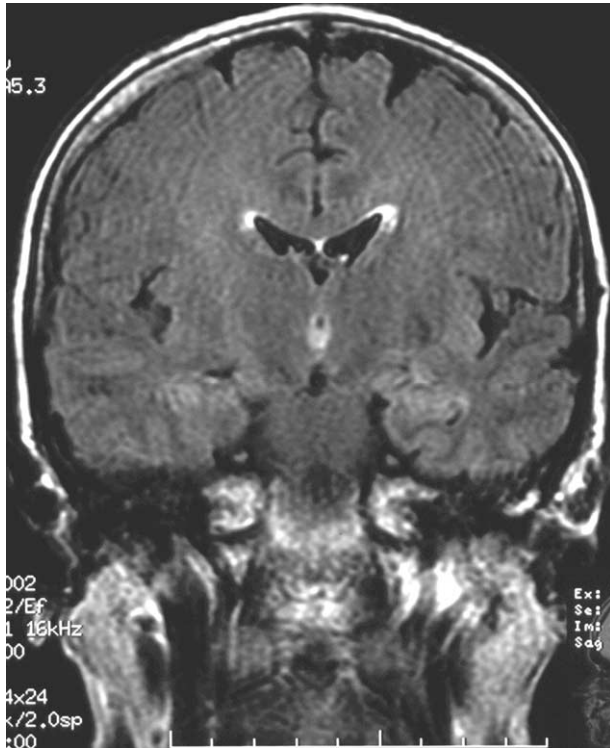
Presence of symmetrical, periventricular white matter degeneration in whole brain MRI after cisplatin treatment. The patient received three weekly doses (50 mg/m^2) leading to a total cumulative dose of 150 mg/m^2 .
